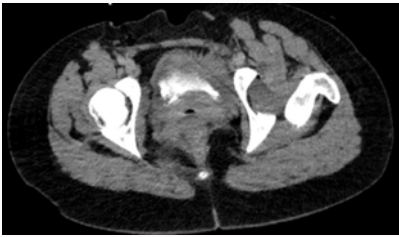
Axial CT Abdomen/Pelvis.
